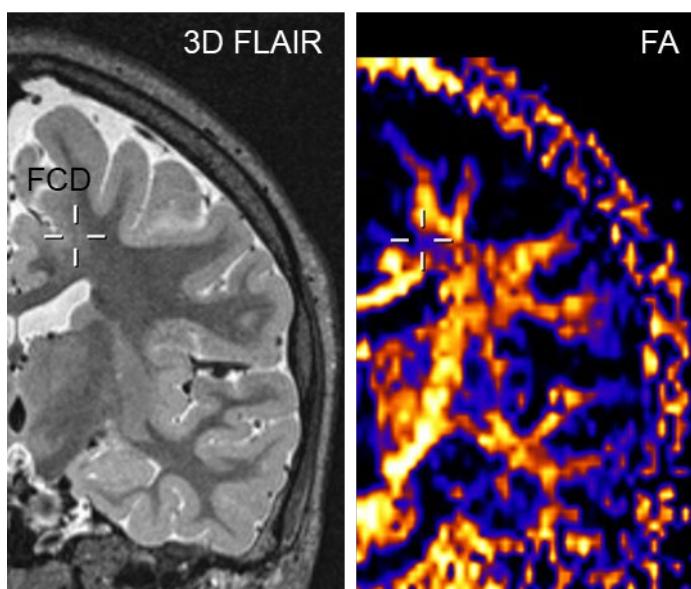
Example of FA reduction in the vicinity of a focal cortical dysplasia (FCD) (see hair-cross and 3D FLAIR co-registering with FA map on the right).
